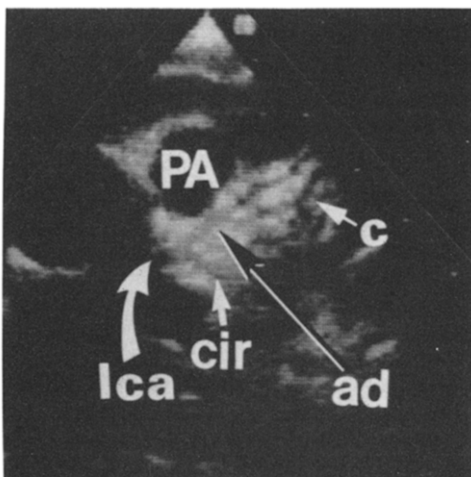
Modified left parasternal short-axis view with slight lateral and superior angulation demonstrating the course of the anterior descending artery (ad) and the presence of an adjacent coronary branch (large conal) (c) that does not originate from the left coronary artery (lca) (see also Fig. 8). Abbreviations in Figure 1.
